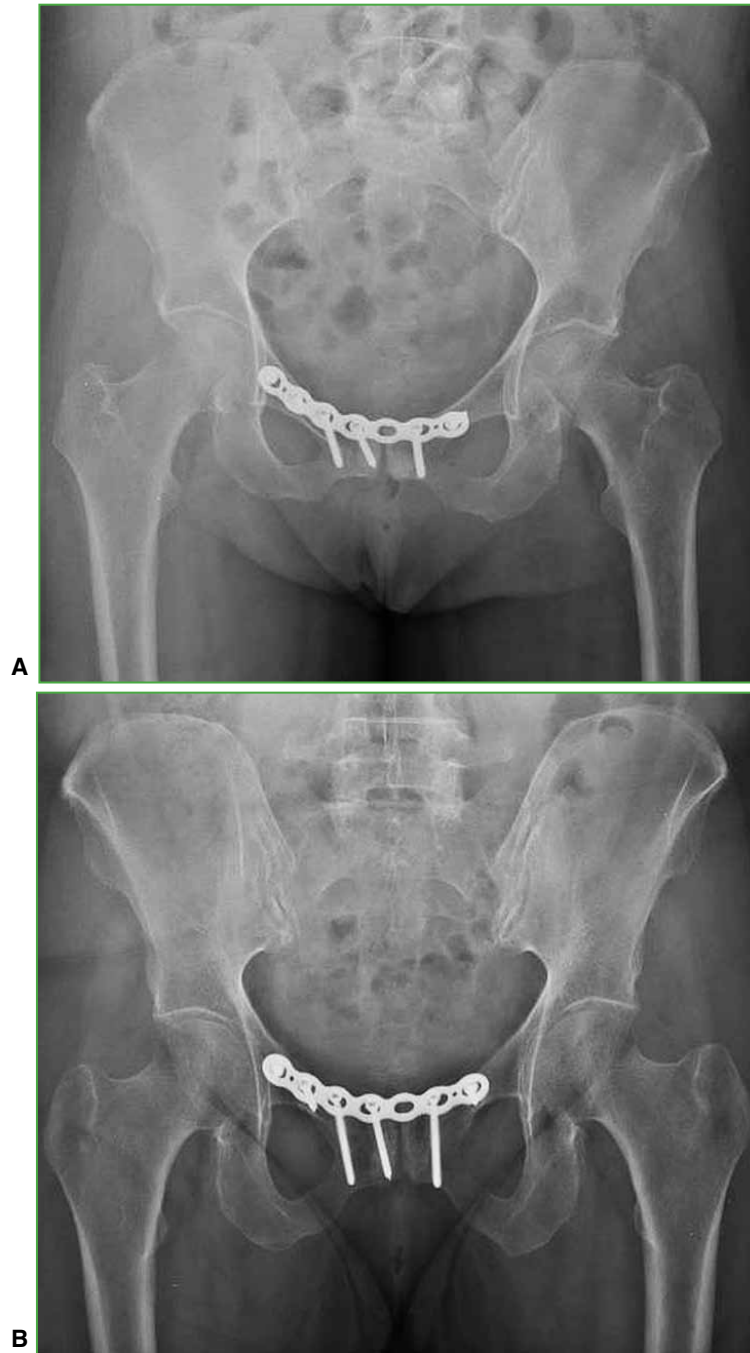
Postoperative clinical images. The plate osteosynthesis with six fixation screws is observed. A. Immediate postoperative radiograph. B. Radiograph at three months. The increase in radiopacity observed at the beginning of treatment is displayed.
